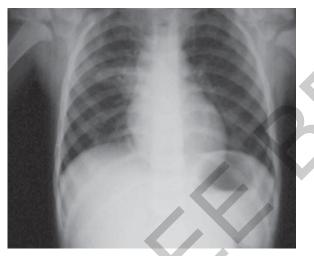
Chest X-ray of a 5-year old with collapse consolidation of the right middle lobe.
